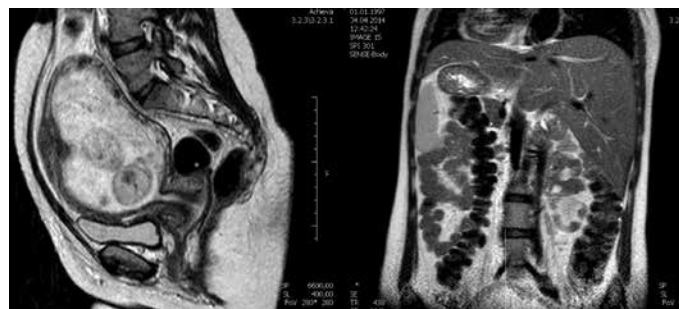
Patient magnetic resonance imaging photos
